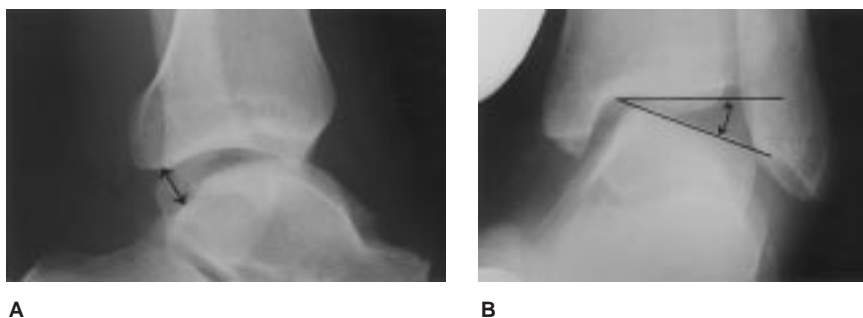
A, Anterior translation of the talus is determined on a lateral stress radiograph by measuring the perpendicular distance (between arrows) from the talus to the posterior articular margin of the tibial plafond. B, Talar tilt is measured on a stress anteroposterior view obtained with the ankle internally rotated 30 degrees (mortise view). (Reproduced with permission from Colville MR: Reconstruction of the lateral ankle ligaments. *Instr Course Lect* 1995;44:341-348.)
